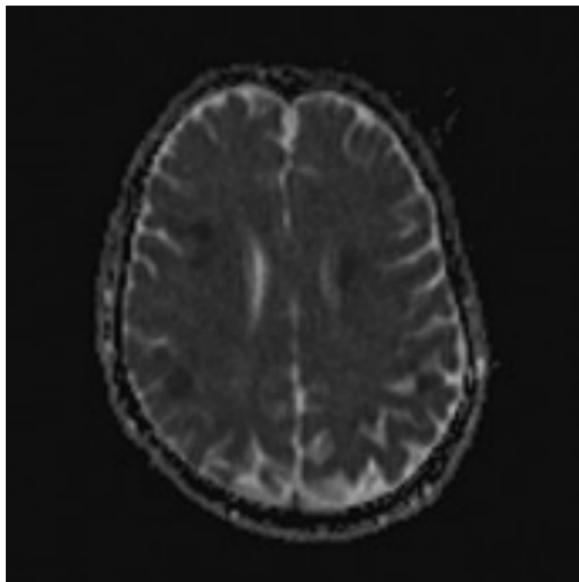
Acute embolic infarcts in patient with atrial fibrillation. (a) DWI axial and (b) ADC map. (a) Multiple small hyperintense areas on DWI consistent with restriction of diffusion. (b) Matching low signal on ADC map. Mainly cortical in distribution. Typical appearances for acute embolic infarcts. Subsequent echocardiogram revealed left atrial thrombus.
